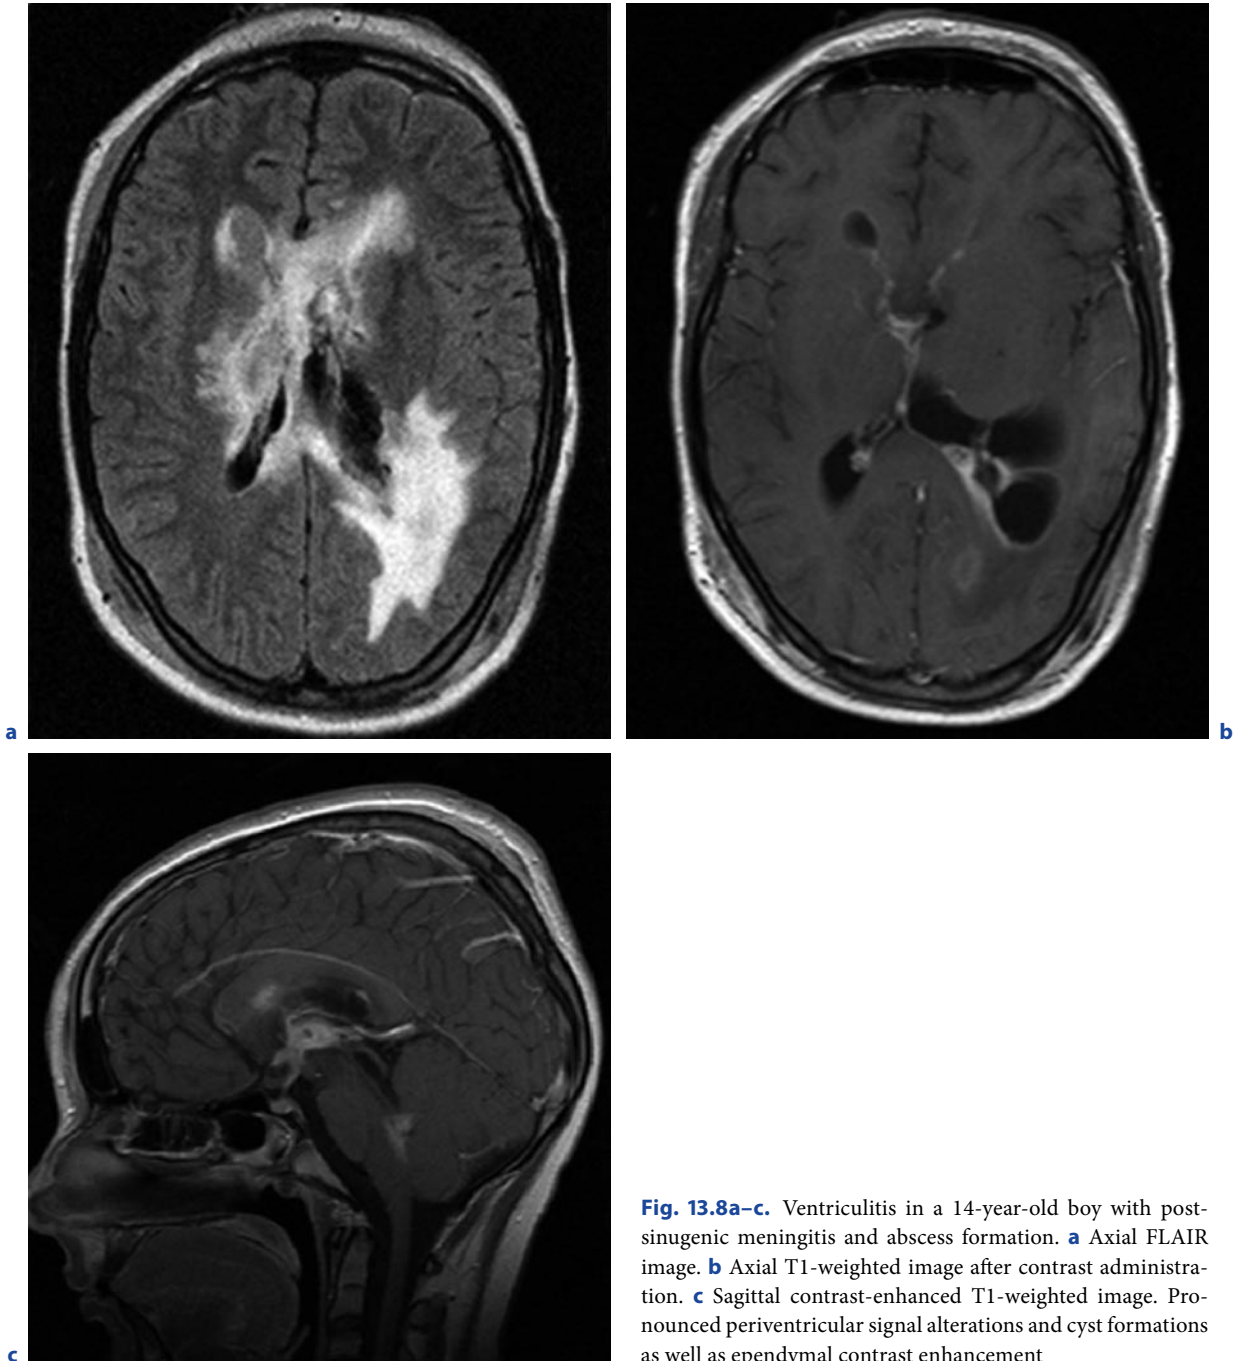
Ventriculitis in a 14-year-old boy with post-sinogenic meningitis and abscess formation. a Axial FLAIR image. b Axial T1-weighted image after contrast administration. c Sagittal contrast-enhanced T1-weighted image. Pronounced periventricular signal alterations and cyst formations as well as ependymal contrast enhancement
